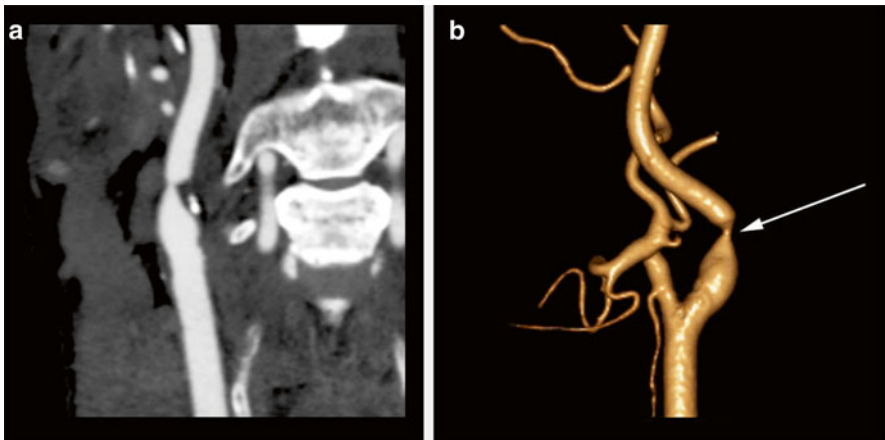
63-year-old male with abnormal carotid Doppler ultrasound. (a) A curved MPR CTA reveals severe stenosis of the proximal right internal carotid artery leading to a “string” sign. (b) A surface-shaded display image shows the degree of focal high-grade stenosis (*arrow*) without the “straightening” of the curved MPR function. This display can be useful for the interventionalist in pre-procedure planning. Images courtesy of Daniel Ginat, M.D.
